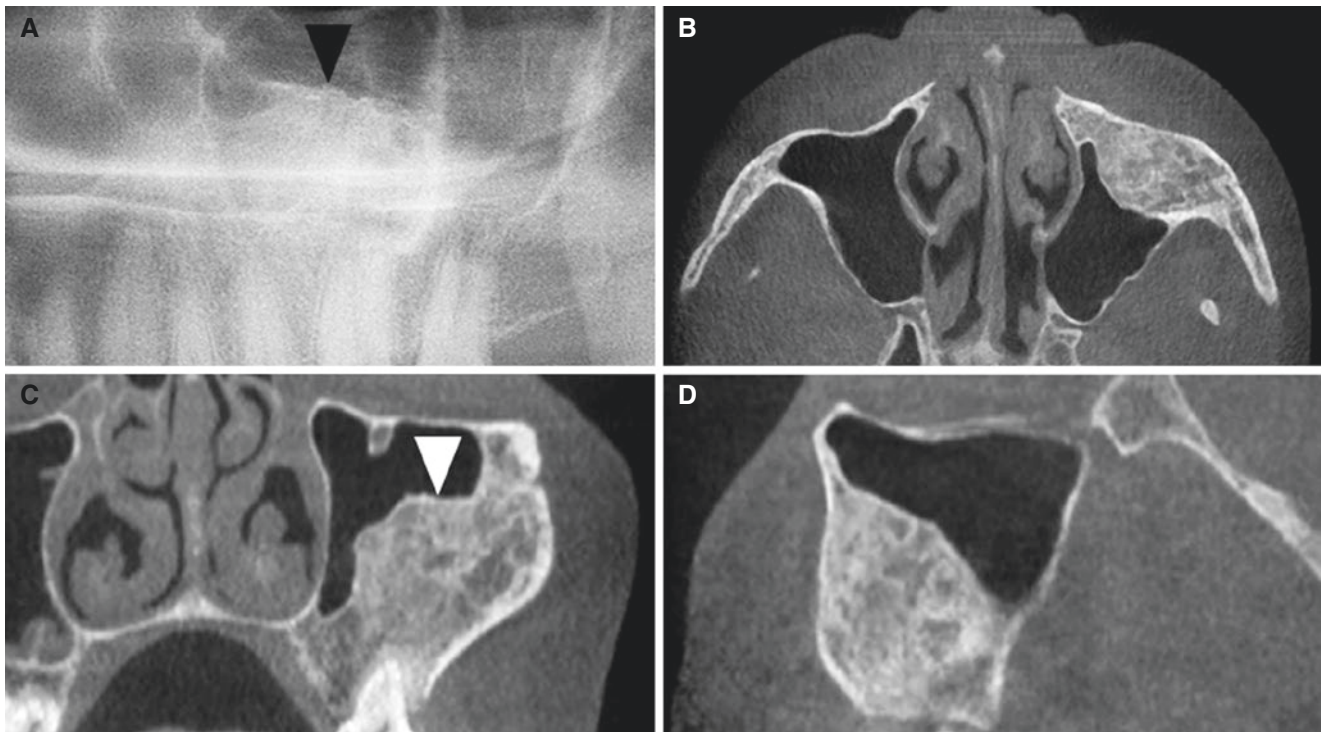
Fibrous dysplasia, maxilla; 51-year-old female with incidental finding. (A) Panoramic view shows radiopacity in the left maxillary sinus (*arrowhead*). (B) Axial, (C) coronal, and (D) sagittal CBCT
